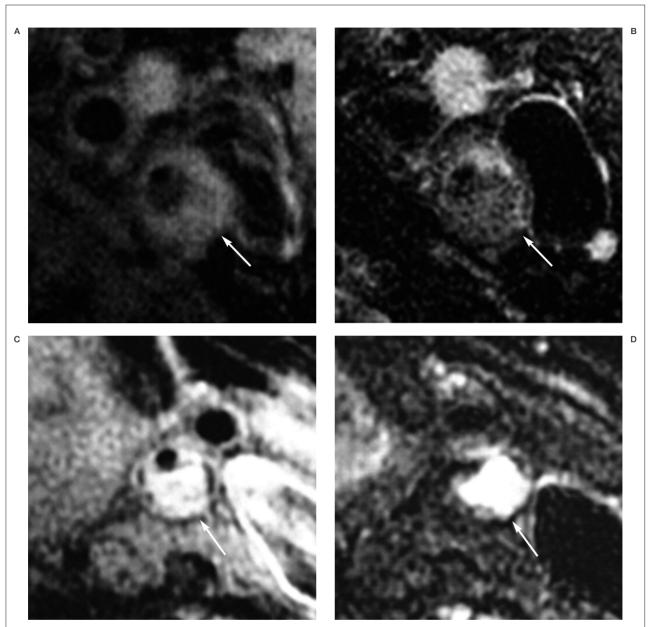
Black blood MRI showing a carotid plaque (white arrow). T1-weighted image shows isointensity (A) and hyperintensity (C). T2-weighted image shows isointensity (B) and hyperintensity (D).
